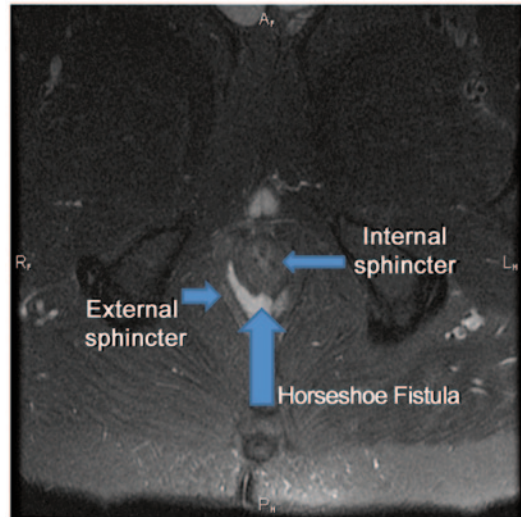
Horseshoe fistula identified on MRI. (Courtesy of Dr. Sid Walker)
